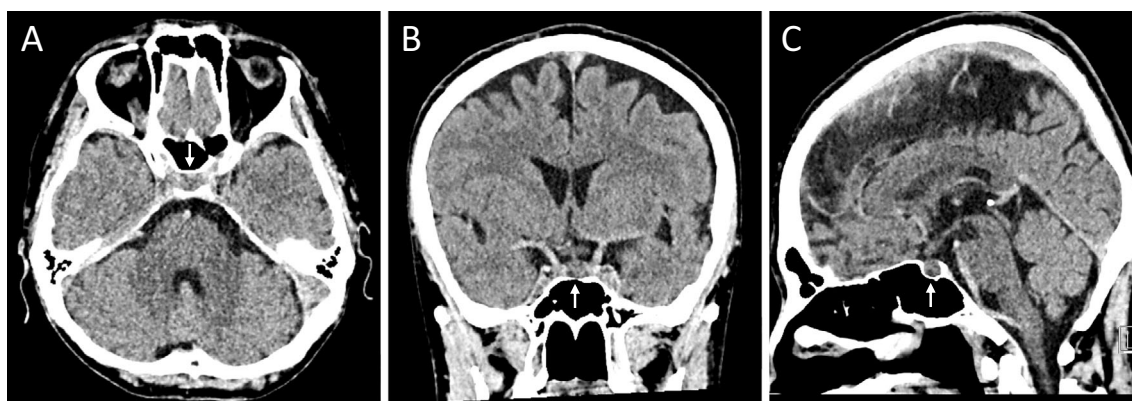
Computed tomography of the head (March 2019). Images in the transverse (A), coronal (B), and sagittal (C) planes.
